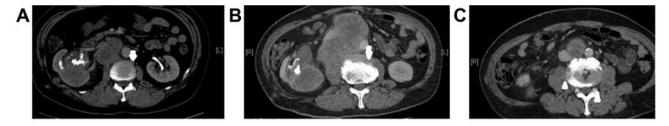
Computed tomographic scan showing direct lumbar vertebral body invasion from renal pelvis carcinoma. Axial view of right renal pelvis malignancy showing a tumor with direct invasion of L2 vertebral body (A), disease progression following chemotherapy with increased L2 vertebral body destruction (B), and L3 vertebral body metastases (C). Arrows indicate tumors with vertebral body invasion. Arrowhead indicates L3 vertebral body bone destruction.
